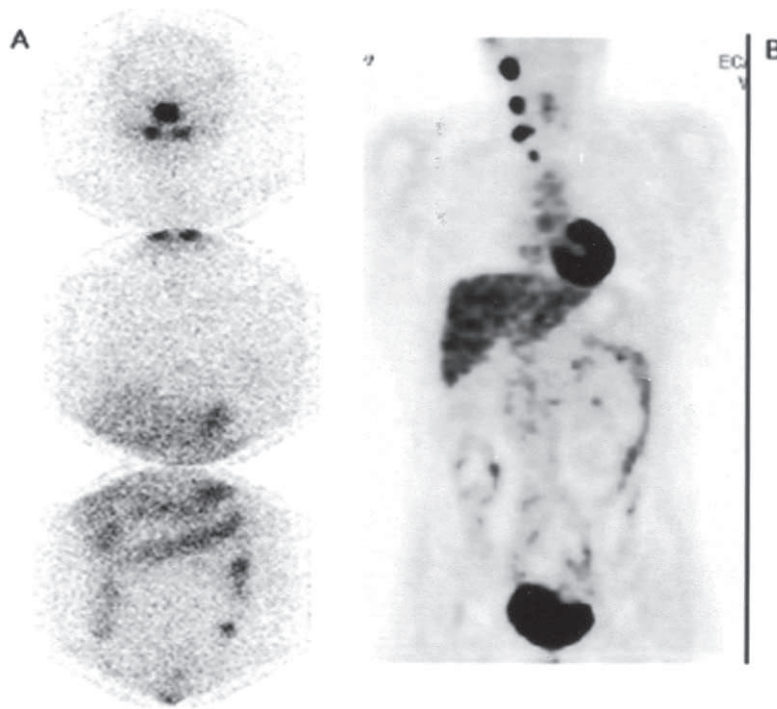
^{131}I whole-body scan and ^{18}F -FDG PET image of a 41-year-old female with papillary thyroid cancer. A: The ^{131}I whole-body scan shows diffuse uptake in the liver without functioning metastases. B: Coronal view of ^{18}F -FDG PET showing multiple increased ^{18}F -FDG uptakes in the right neck.
